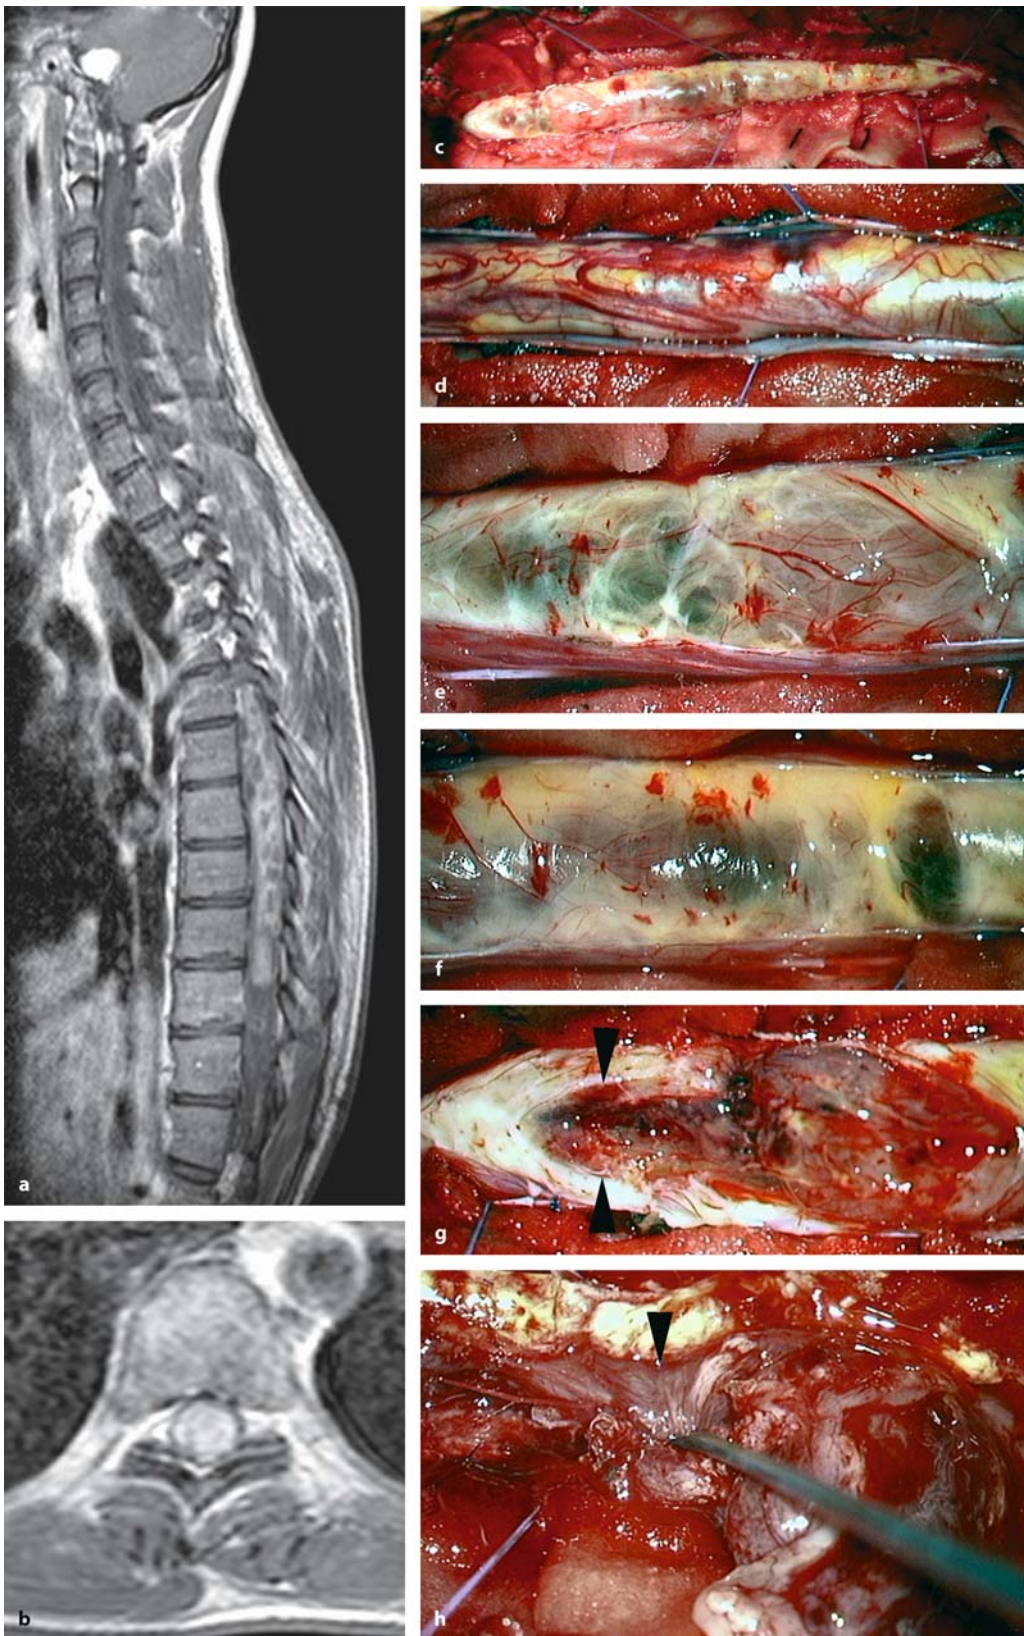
T1-weighted, contrast-enhanced sagittal (a) and axial (b) MRI images of an intramedullary WHO grade I astrocytoma at C6-C7 in a 23-year-old woman with a 10 year history of right sided arm pain progressing to a slight tetraparesis. There is no significant syrinx associated with the tumor that is located on the right side. c The intraoperative view on the spinal cord in the semisitting position displays no visible
